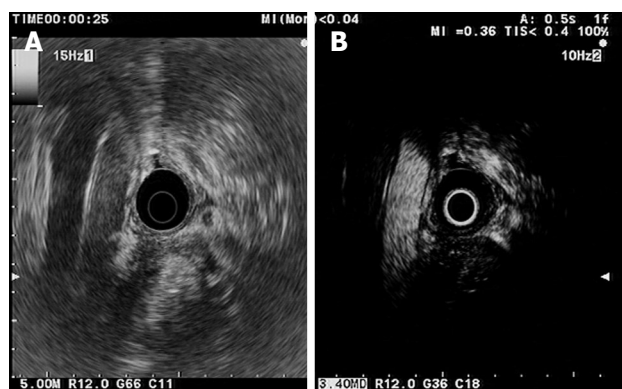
Mass resembling chronic pancreatitis. A: Conventional endoscopic ultrasonography (EUS). Hypoechoic inhomogeneous mass in the pancreatic head. Aorta and inferior caval vein are also seen; B: Contrast-enhanced harmonic-EUS. During the arterial phase (25 s after contrast injection) the abdominal aorta becomes hyperechoic and the mass is hypovascular compared with surrounding parenchyma.
